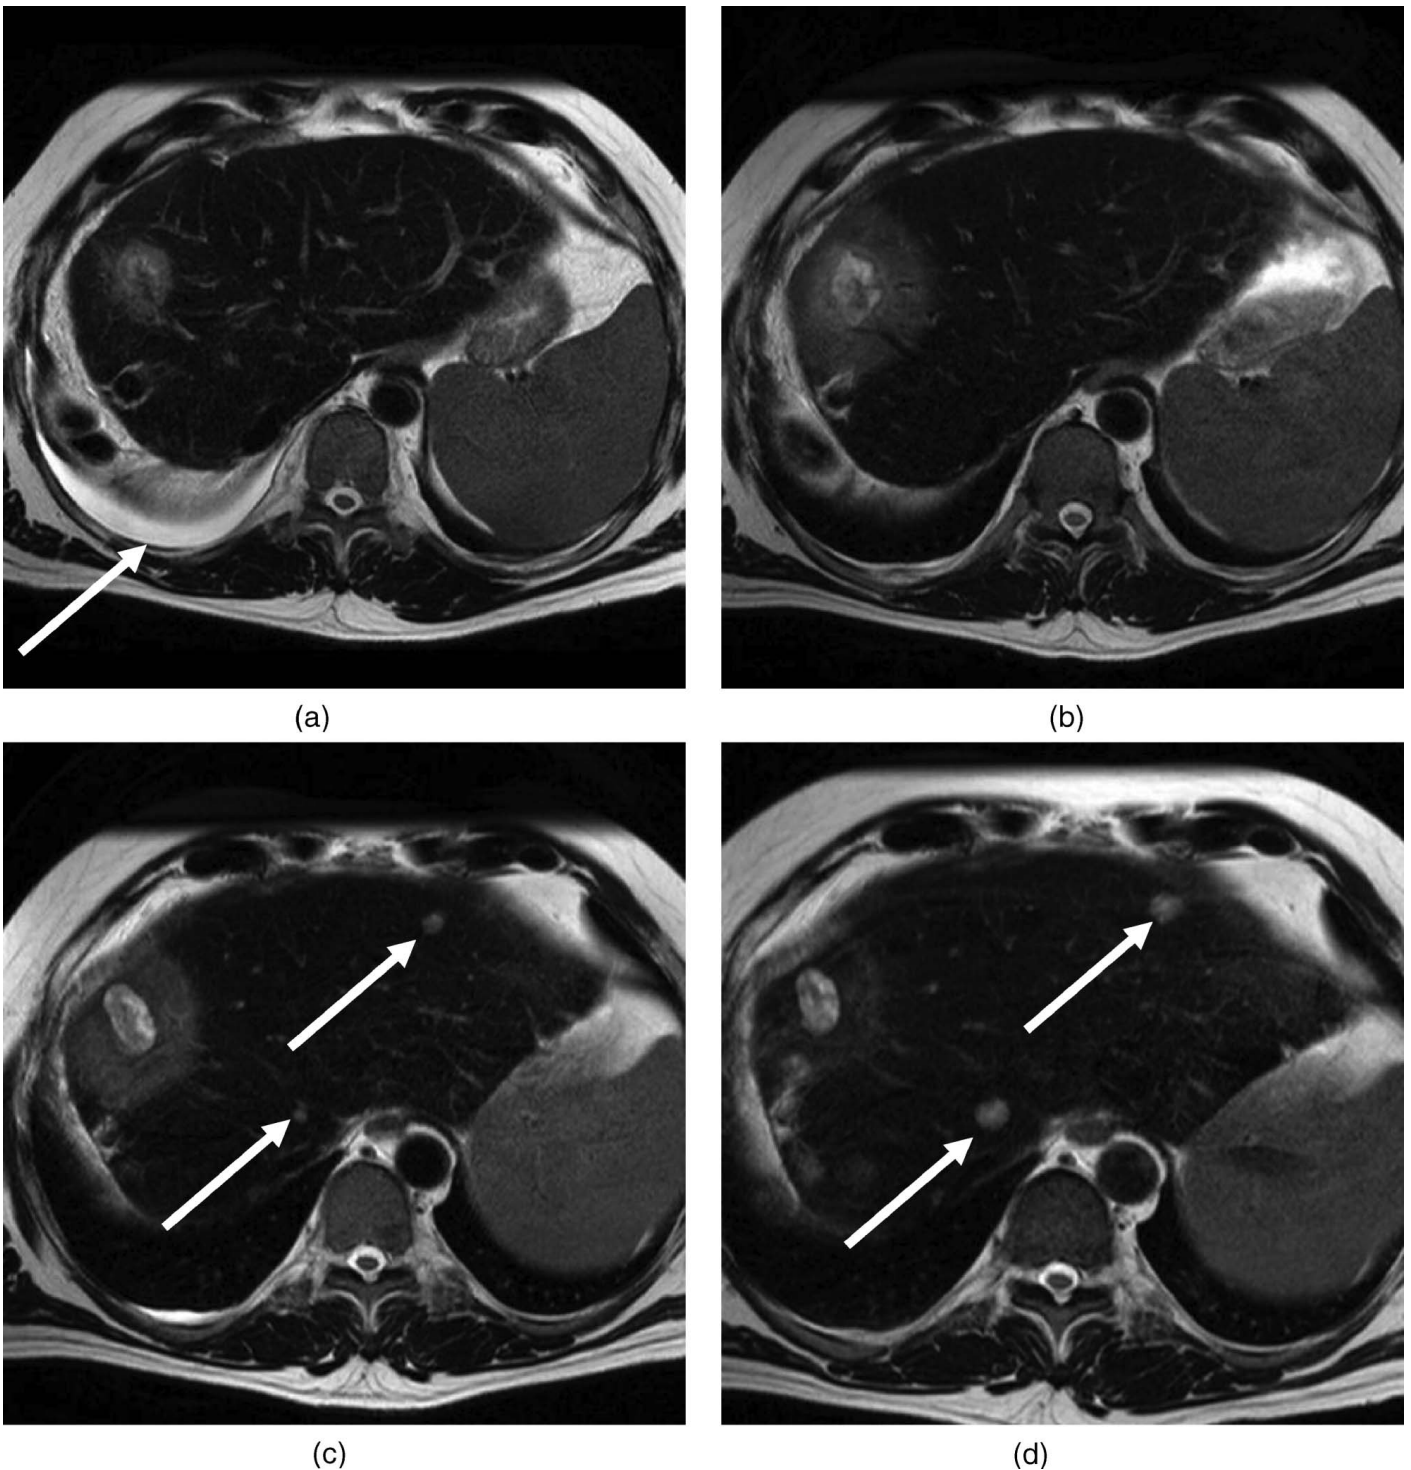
MRI acquired 3 days (a), 6 weeks (b), 12 weeks (c) and 24 weeks (d) after brachytherapy. T2-w TSE post i.v. application of SSPIO. Development of a hyperintense rim around the tumor lesion through diminished uptake of contrast agent indicating hepatic RES dysfunction. Note in figure (a) a small pleural effusion (arrow) after treatment and in figures (c & d) a manifestation of new metastasis (arrows) under chemotherapy and no progression of the treated metastasis after CT-guided brachytherapy. No further local treatment of the new liver metastases was performed due to multiple intra- and extrahepatic tumor deposits.
